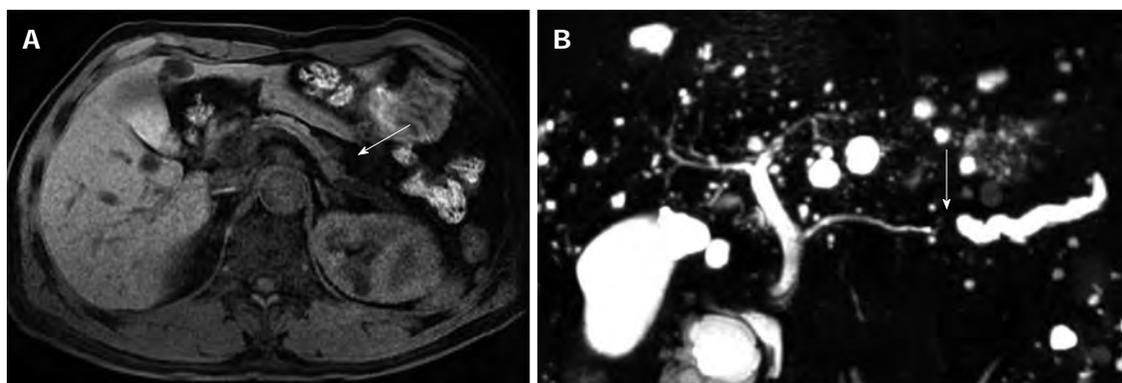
Magnetic resonance image of 61-year-old male patient with normal serum immunoglobulin G4. A: Magnetic resonance image shows slightly exophytic mass of iso-attenuation at the body of pancreas; B: Distal parenchymal atrophy and abrupt cutting of pancreatic duct with upstream ductal dilatation.
